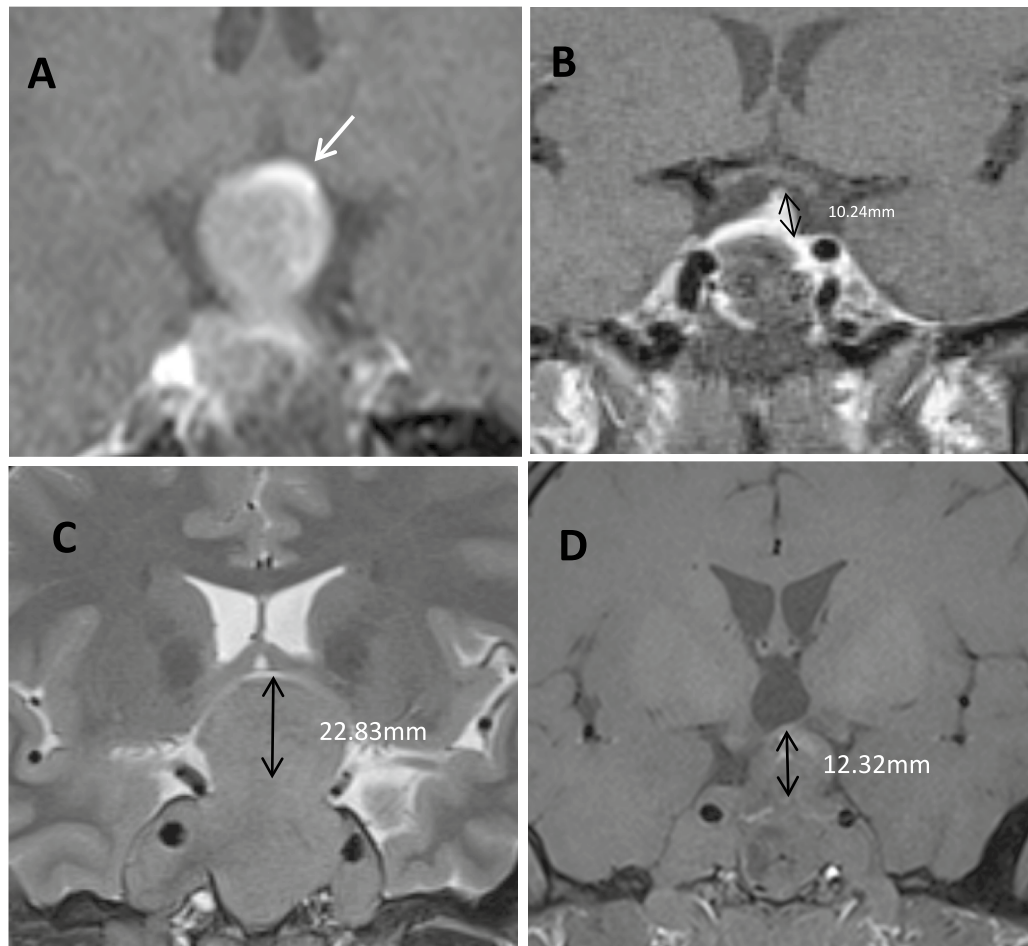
(A,B) Measurement of “preoperative pituitary stalk length” on MRI T1-enhanced images. (A) Preoperative imaging shows a curved pituitary stalk (white arrow) compressed by a pituitary tumor, with a measured length of 0 mm. (B) Postoperative elongation of the pituitary stalk, with a length of 10.24 mm labeled as “postoperative pituitary stalk.” (C,D) MRI-T2WI showing the measurement of the sellar diaphragm height (the distance between the plane where the sellar diaphragm height begins to ascend and the plane of its highest point). (C) The preoperative elevation height of the sellar diaphragm height was 22.83 mm. (D) The postoperative elevation sellar diaphragm height was 12.32 mm. The descent depth of the sellar diaphragm height is the difference between the two values (22.83–12.32 mm).
